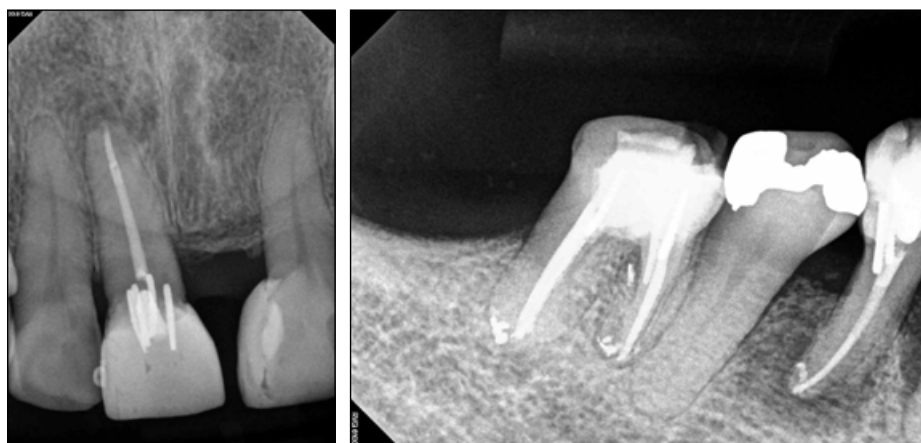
Periapical radiographs taken following successful endodontic treatment of the 11 and 44.
